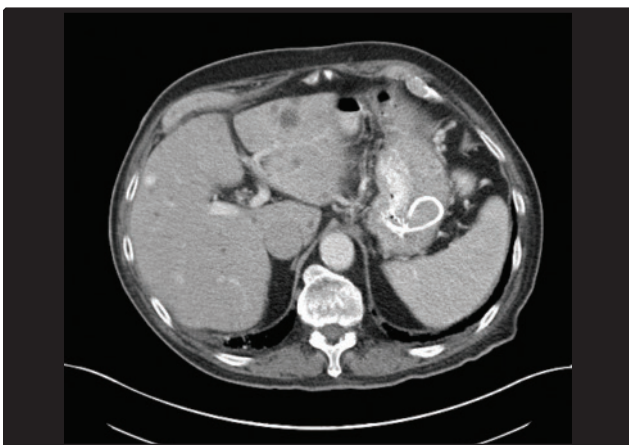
CT scan obtained one month after stent placement. The pseudocyst has resolved and the stents are seen in situ.
